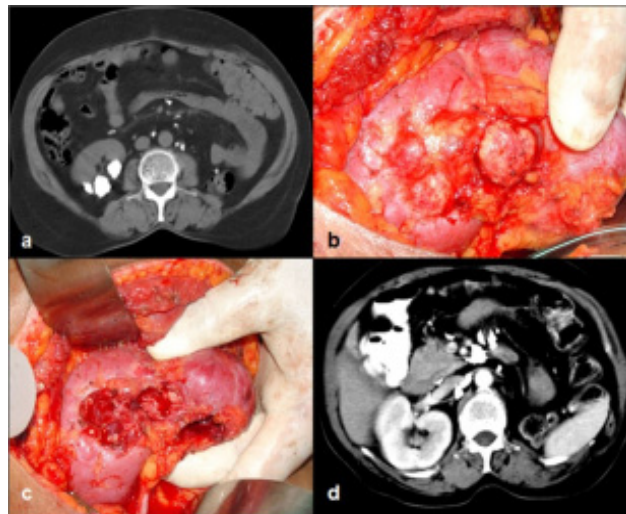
CT images before and after excision of calcified mass.
